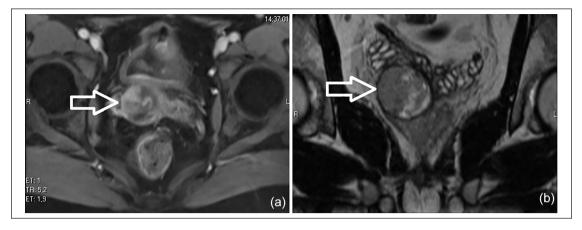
(a, b) CT scan showed a necrotic mass of 34 mm in contact with the prostate and the right seminal vesicle.
